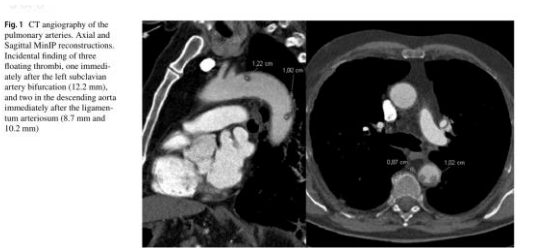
CT angiography of the pulmonary arteries. Axial and Sagittal MIP reconstructions. Incidental finding of three floating thrombi, one immediately after the left subclavian artery bifurcation (12.2 mm), and two in the descending aorta immediately after the ligamentum arteriosum (8.7 mm and 10.2 mm)
